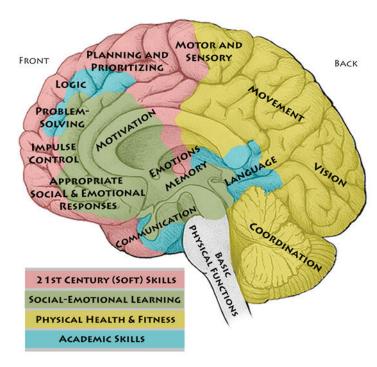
How Afterschool Impacts Brain Development. Reprinted from Brain-Building in Afterschool by E. Scott, 2016, Hartford, CT: Connecticut After School Network. Retrieved from http://ctafterschoolnetwork.org/brain-building-in-afterschool/. Copyright 2016 by the Connecticut After School Network. Reprinted with permission.
